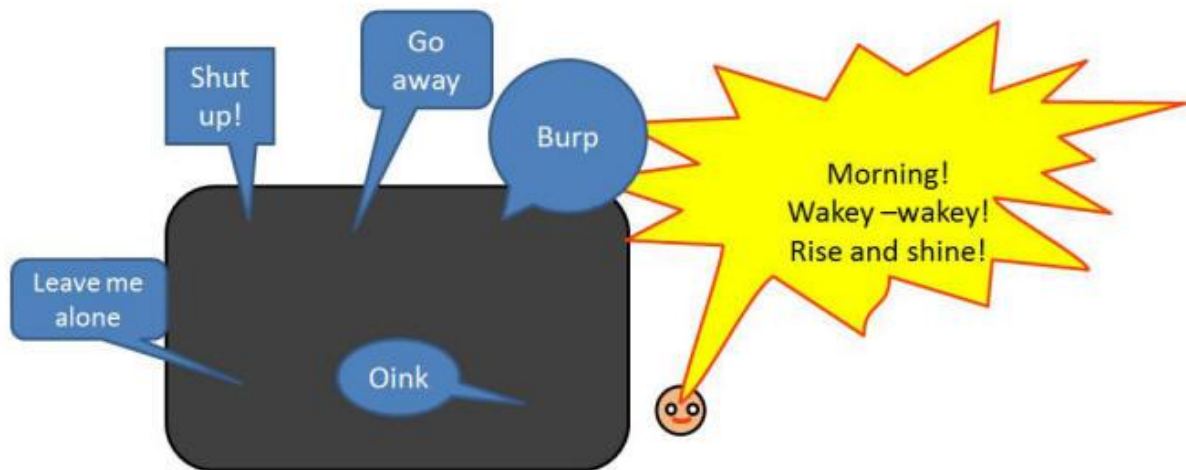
Analogy to explain MRI Part 2
